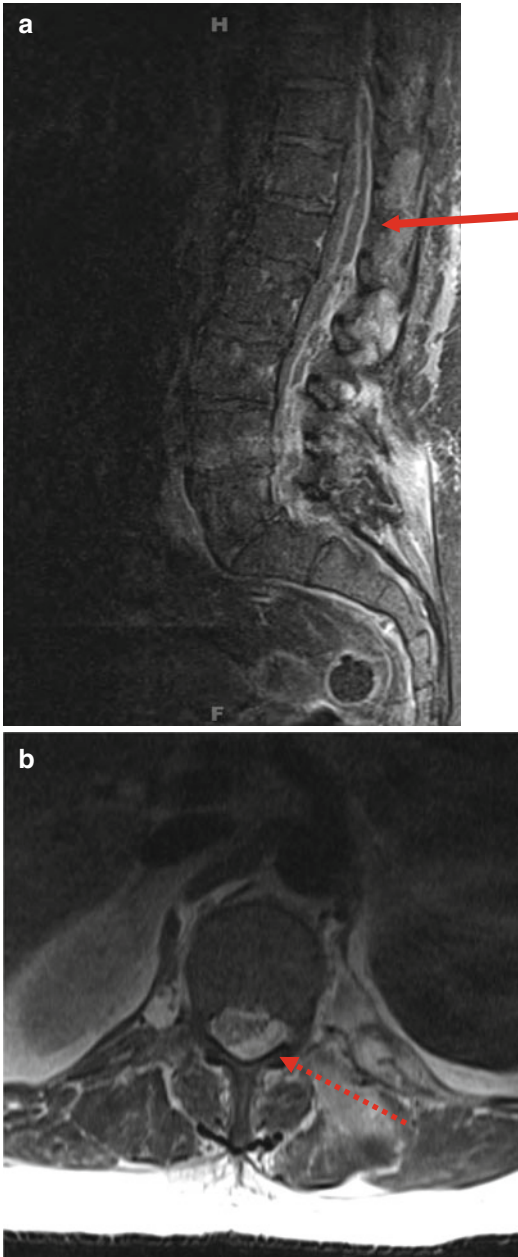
Images of a 64-year-old male with a thoracolumbar epidural abscess. He presented with 3 weeks of increasing pain and progressive left leg weakness. Initially he received a left hip intra-articular injection, as this was thought to be the origin of his pain. He subsequently became febrile and also developed mental status changes and constipation. Sagittal T1 MRI with contrast (a) demonstrated a ring-enhancing posterior epidural lesion extending from T11 to L5 that compressed the spinal sac (*solid arrow*). Axial T2 MRI without contrast (b) further elucidated the degree of spinal sac compression (*dashed arrow*). After operative debridement via an L1-L4 hemilaminectomy, cultures grew *Staphylococcus aureus*. The patient recovered full neurological function
